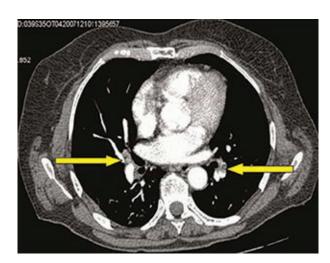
CT scan shows filling defect in pulmonary arteries.
